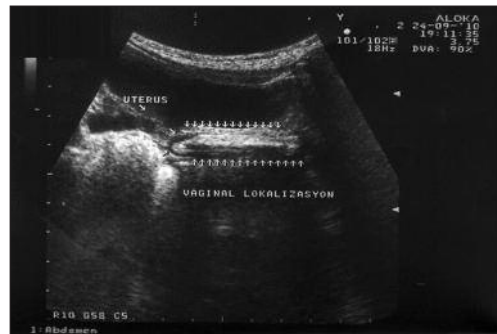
Vaginal foreign body, ultrasound image.
